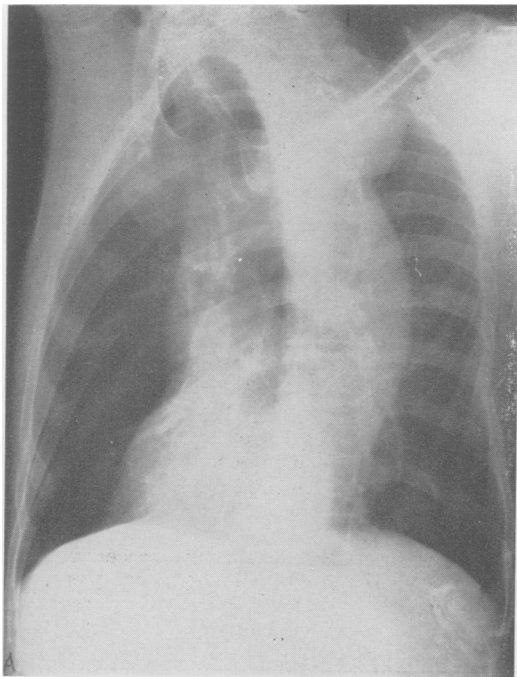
Roentgenogram of chest in Case 4, in oblique projection, showing aneurysm arising from the distal portion of the aortic arch.
